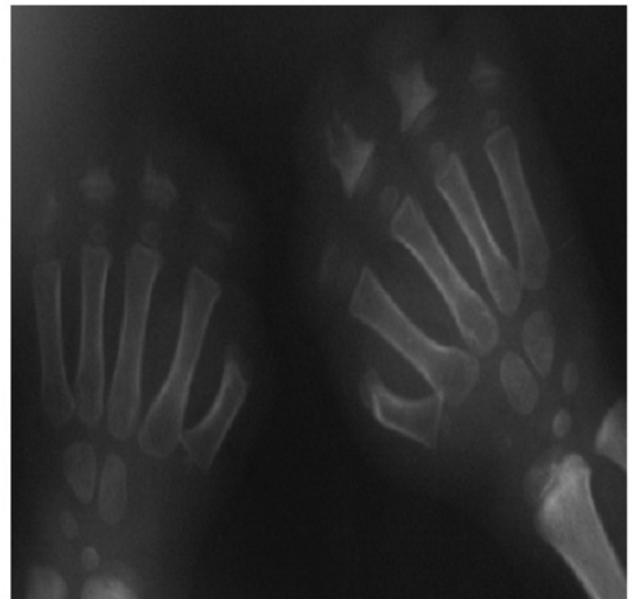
Without the ability to feel pain, injury and destruction of tissue results. This radiograph shows destruction of fingers in a child suffering from congenital insensitivity to pain. Reprinted with permission from Labib S, Berdai M, Abourazzak S, Hida M, Harandou M. Congenital insensitivity to pain with anhidrosis: report of a family case. *Pan African Medical J.* 2011;9:33.
